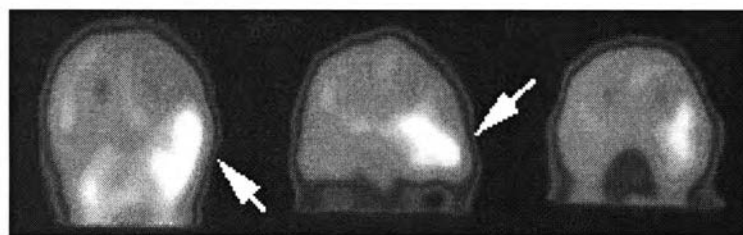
Ictal SPECT in temporal lobe epilepsy
